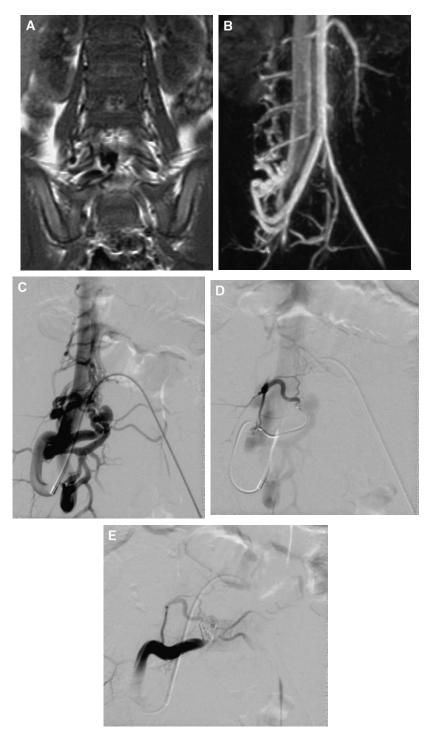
(A) MRI and (B) magnetic resonance angiography demonstrate abnormally dilated extradural vessels in an 18-month-old girl. (C) Right internal iliac artery injection shows an extradural arteriovenous fistula. (D) The microcatheter is positioned on the venous side of the fistula. (E) Selective internal iliac artery injection after coil embolization of the fistula confirms its complete obliteration without venous shunting. The patient remains neurologically intact.
